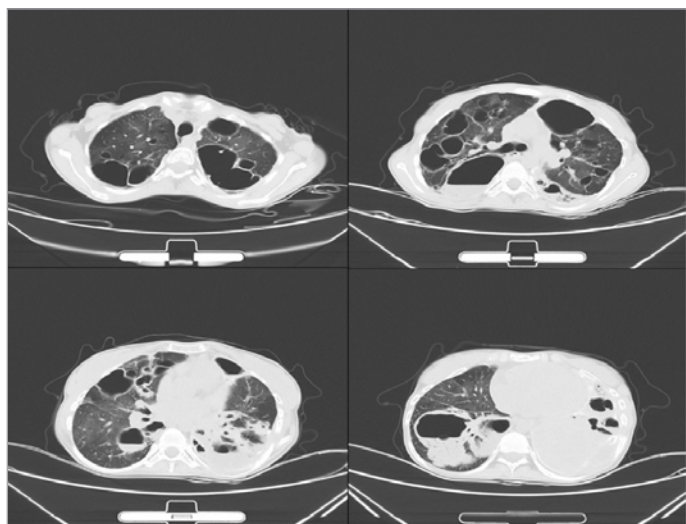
Axial CT scan of the thorax showing bilateral large pneumatoceles with air fluid level and thin-walled cystic lung changes.
